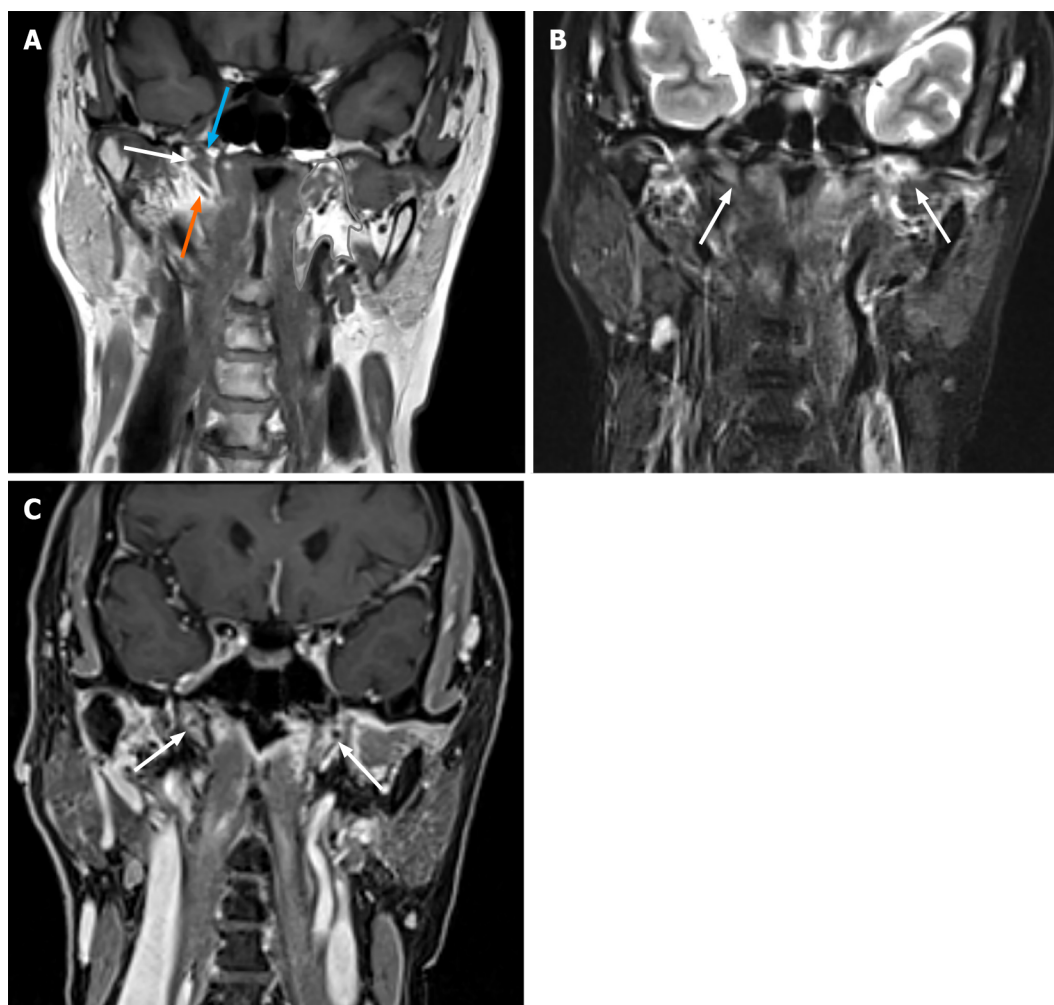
Non-contrast-enhanced and contrast-enhanced images of the patient. A: Non-contrast-enhanced T1-weighted image of the patient. The Eustachian tube (white arrow) is located in the parapharyngeal space (contoured area). The Merkmal of the Eustachian tube is the levator veli palatine muscle (blue arrow) on the upper side and tensor veli palatine muscle (orange arrow) on the lower side; B: Non-contrast-enhanced fat-saturated T2-weighted image of the patient demonstrated edematous bilateral eustachian tube (white arrow); C: Contrast-enhanced 3D-volumetric interpolated breath-hold examination T1-weighted image demonstrated enhanced bilateral Eustachian tube (white arrow).
